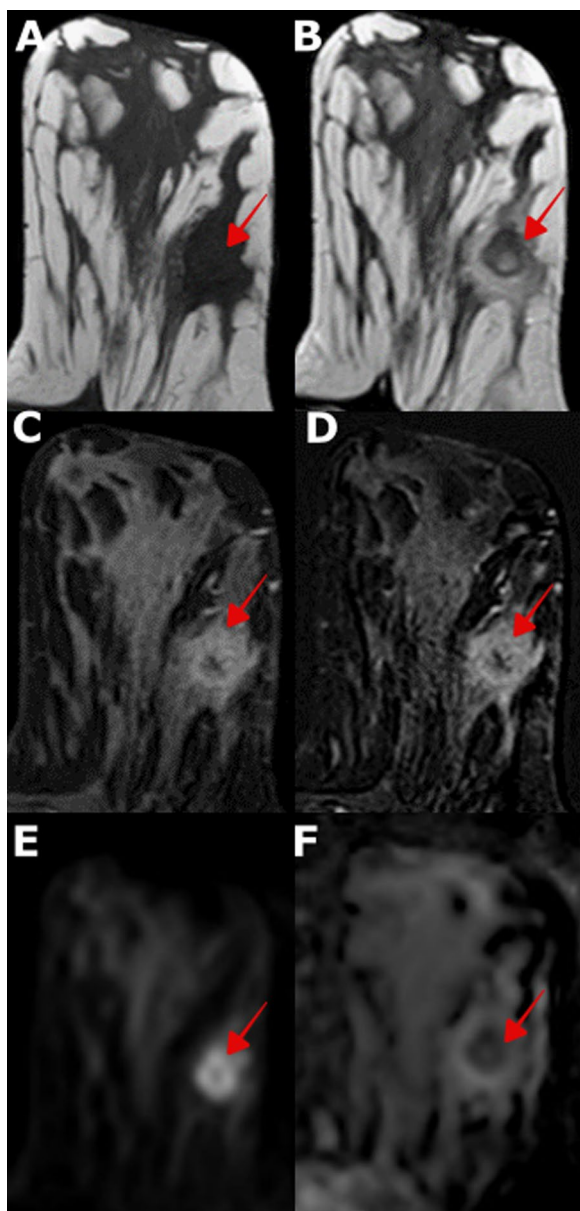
A female patient aged 30 years old complaining of left breast lump. She had no previous family history of breast cancer, nor had she received hormonal contraception before. MRI revealed: A & B Pre-contrast T1- and T1-weighted axial images showing: a mass lesion of low signal intensity at the left breast's upper outer quadrant (UOQ) surrounded by peritumoral high signal intensity on T2 WI. C & D Post-contrast dynamic and subtraction axial images showing: marginal heterogeneous enhancement. at UOQ of the left breast. E & F DWI shows marginal high signal intensity with low signal in ADC map with mean lesion ADC value = 0.85×10^{-3} mm/sec and perilesional ADC = 1×10^{-3} mm/sec. Pathology proved to be high-grade invasive ductal carcinoma—Triple-negative subtype—Ki-60%
